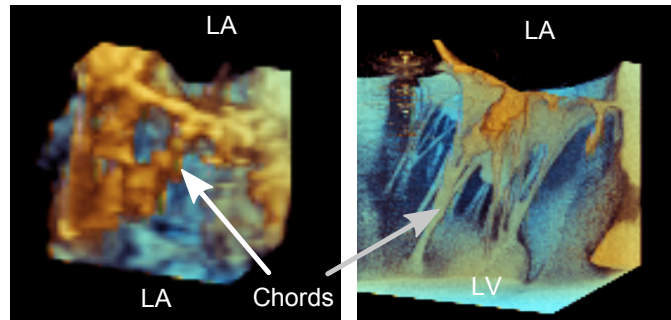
The mitral valve chords from the same valve as seen in (*Left*) 3DUS (transesophageal, 4-chamber approach) and as seen in (*Right*) micro CT. The lack of definition of the chords in 3DUS explains why accurate chordal segmentation from clinical 3DUS remains a challenge. (LA - left atrium, LV - left ventricle)
